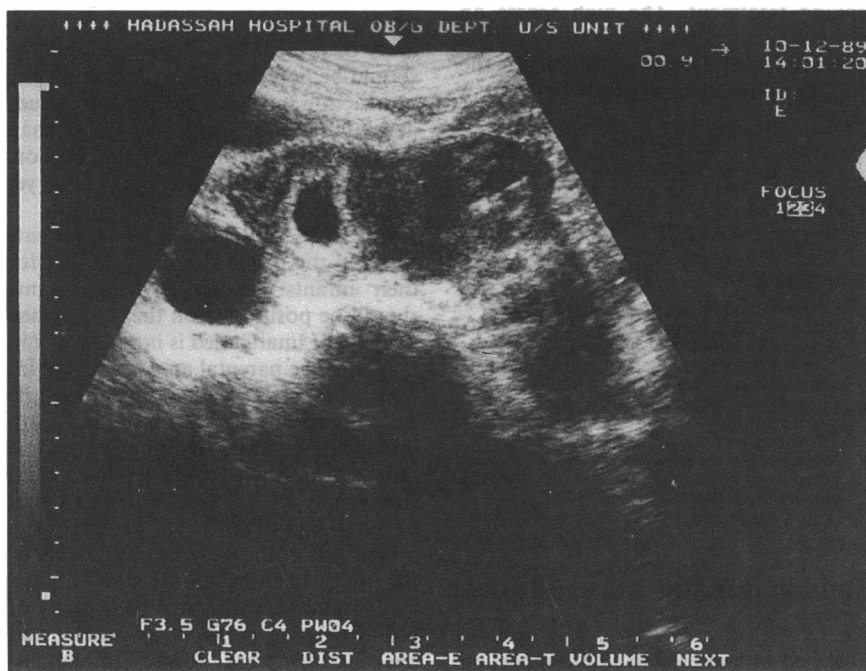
Ultrasound scan of bicornuate uterus showing intrauterine contraceptive device on the right and pregnancy sac and corpus luteum on the left.
